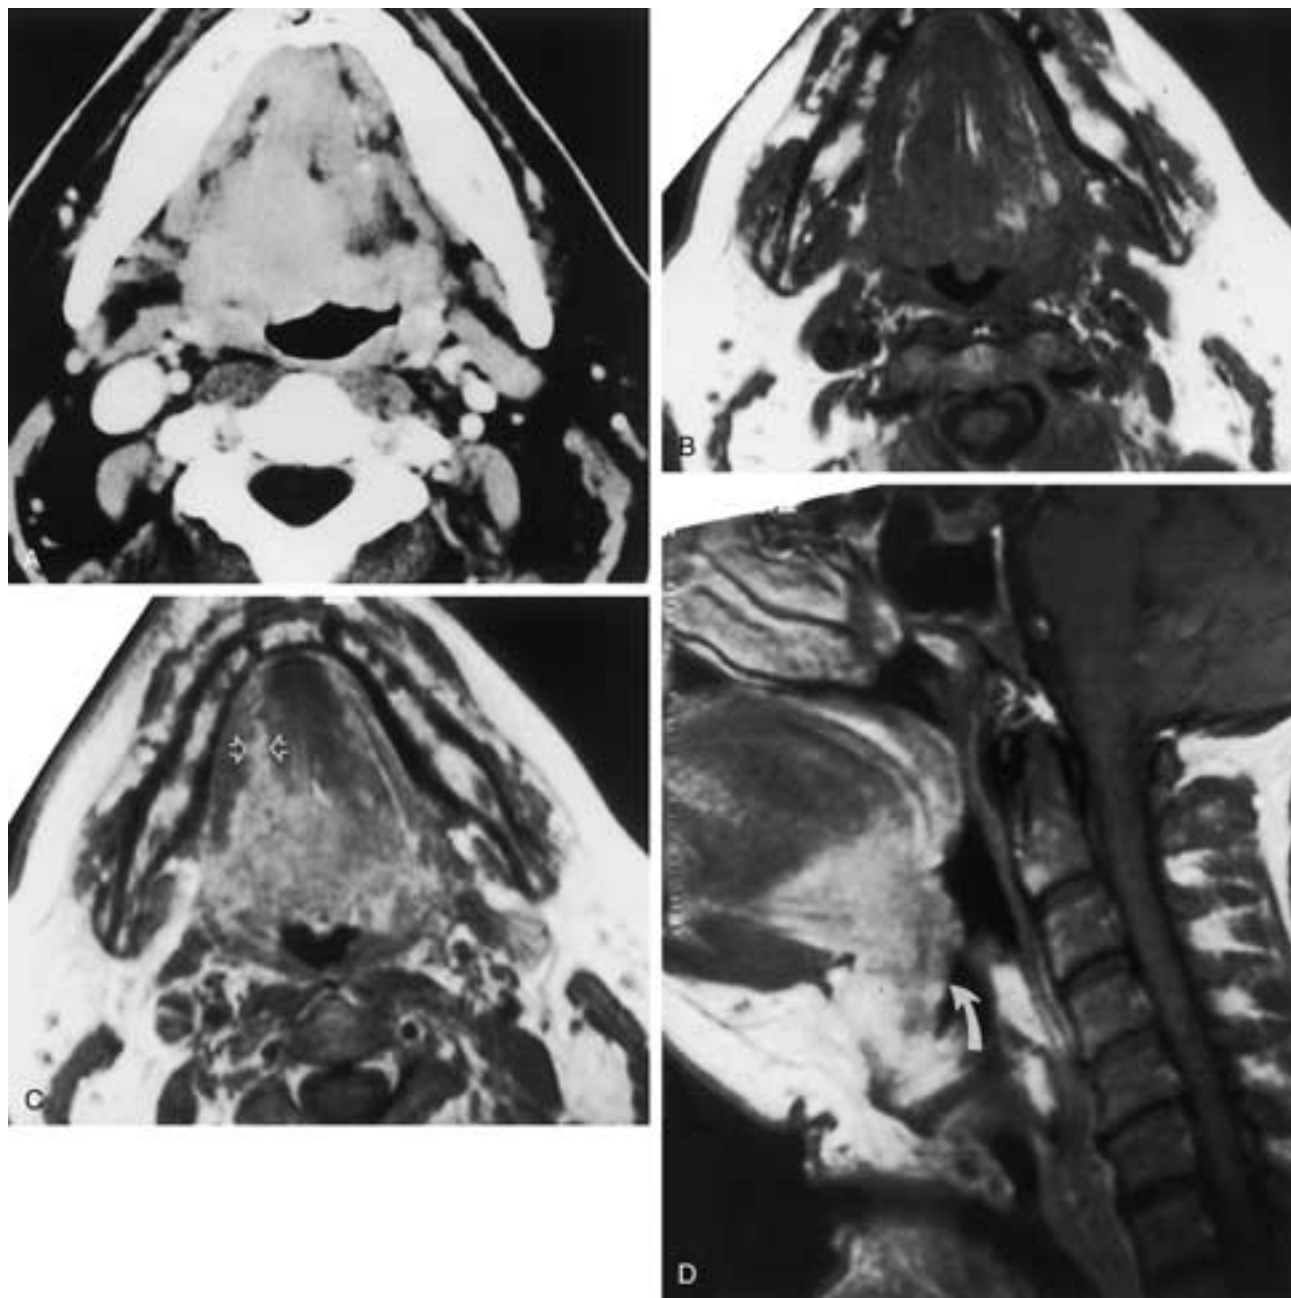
Squamous cell carcinoma of the oral tongue/tongue base. A, Contrast-enhanced axial CT scan demonstrates a large, fairly well defined tumor centered in the region of the circumvallate papillae crossing the midline. B, T1-weighted MR image without contrast enhancement demonstrates the tumor to be isointense to muscle and very difficult to define. Axial (C) and sagittal (D) T1-weighted MR images with contrast enhancement more clearly demonstrate the tumor extension to involve virtually the entire tongue base and the right sublingual region far anteriorly between the medial margin of the mylohyoid muscle and the lateral margin of the genioglossus muscle (arrows in C). The oropharyngeal extension inferiorly to the epiglottis is best appreciated on the sagittal image (arrow in D), as is the anterior extension along the floor of the mouth.
